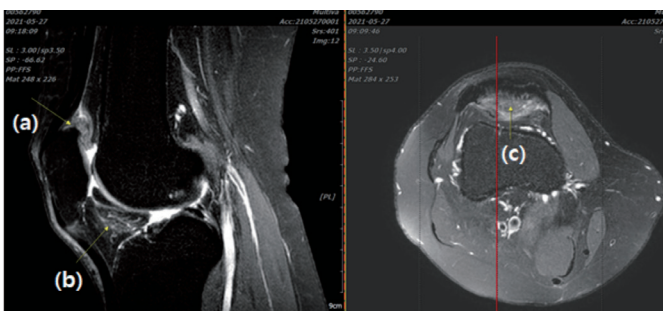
Magnetic resonance imaging of the right knee (May 27, 2021). Tissue edema in the anterior suprapatellar fat pad (arrow A, C) and Hoffa's fat pad (arrow B).
